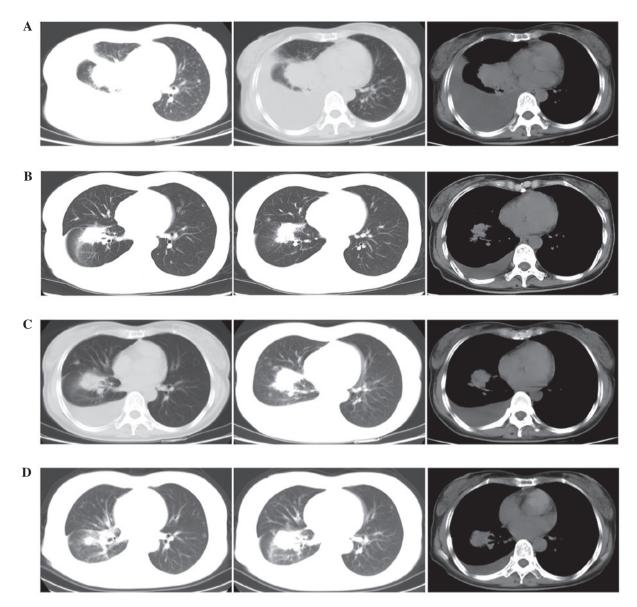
Thoracic computed tomography scans ahowing (A) disease progression prior to afatinib treatment (July 9, 2014), (B) partial response to afatinib treatment (August 27, 2014) and (C) disease progression following 3 months of afatinib treatment (October 8, 2014). (D) The right lung lesion and pleural effusion were shown to have shrunk and stabilized following the addition of bevacizumab to afatinib treatment (January 14, 2015).
